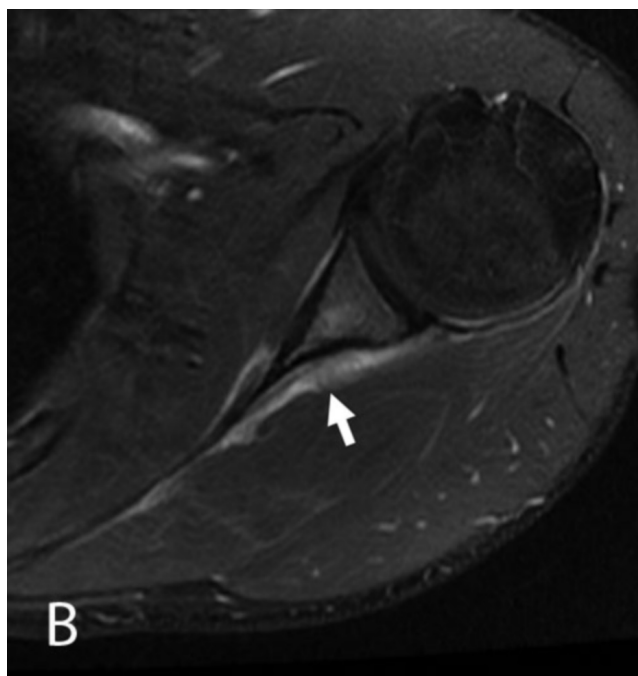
17-year-old male with scapular stress fracture. Comparison of a healing fracture (A and B) and lymphoma of the scapula (C) both in two separate 17-year-old-males. Axial imaging through the scapula in the youth with the healing fracture shows marrow edema and enhancement with periosteal reaction throughout the scapula. (A) T2-weighted, fat-saturated image shows increased signal intensity in the marrow cavity and periosteal reaction (arrow). (B) T1-weighted, fat-saturated imaging shows enhancement of the marrow and periosteum. A second male with lymphoma of the scapula shows similar findings on enhanced T1-weighted, fat-saturated imaging (C).
